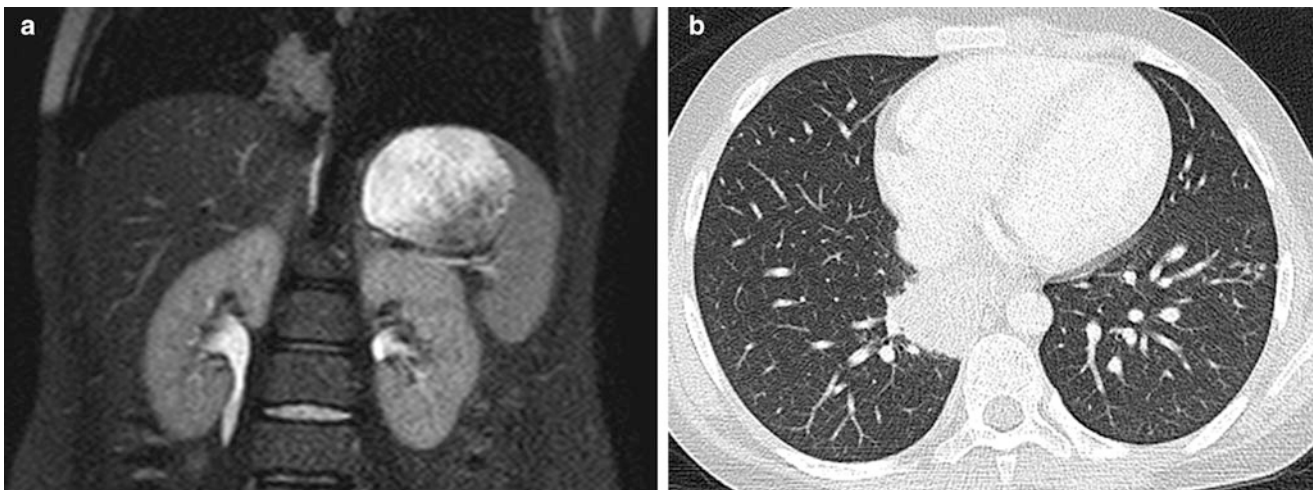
Pulmonary Crohn disease. A coronal T2-weighted MR image (a) obtained during an MR enterography study on an 11-year-old boy with Crohn disease reveals a mass-like intermediate-to-high signal intensity lesion of the medial basilar right lower lobe. An axial chest
